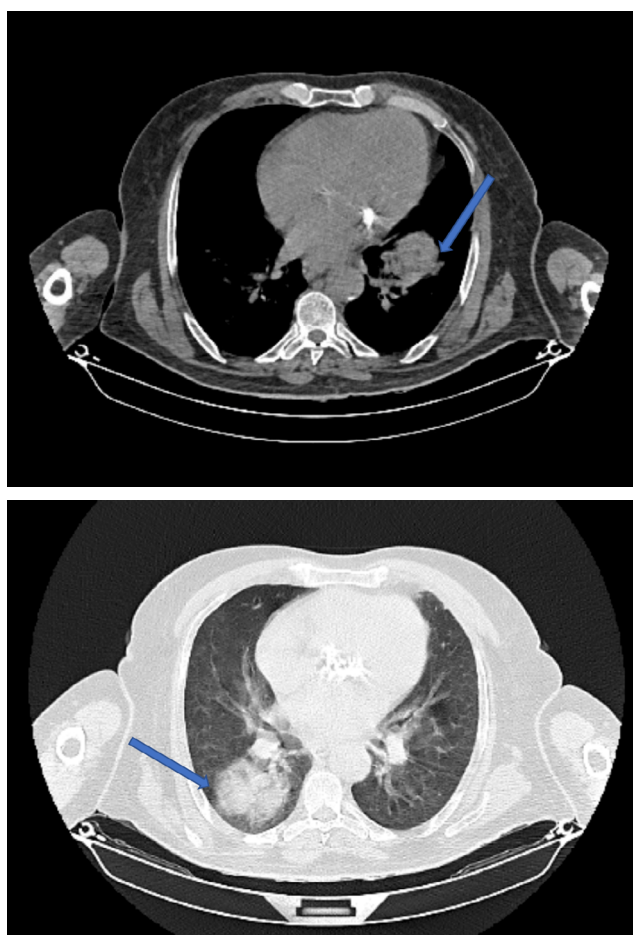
Thoracic computed tomography (CT) scan.
